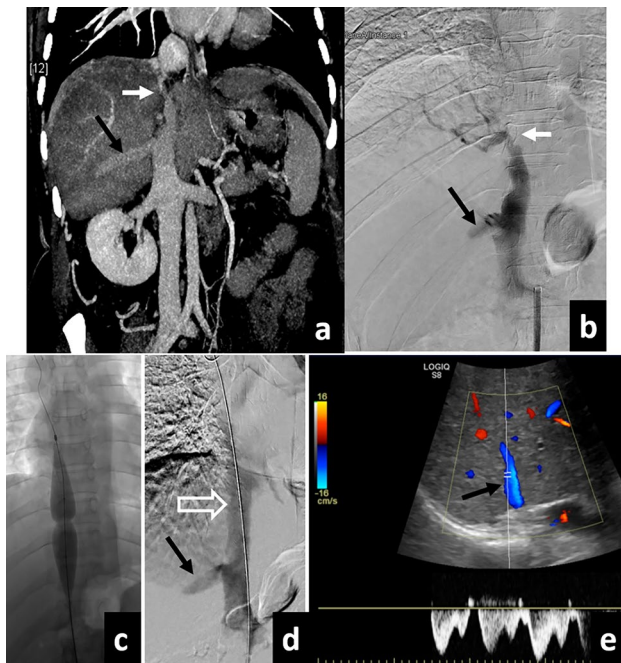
Segmental IVC recanalization through transfemoral route in a patient with abdominal pain and lower limb swelling. a Coronal CECT showing short-segment intrahepatic IVC obstruction due to IVC web and associated chronic eccentric thrombus (white arrow a). The liver was draining mainly through right AHV (black arrow). b IVC venogram confirmed the CT findings (white arrow b). c Stricture was crossed and balloon angioplasty was done using a 20 mm balloon. d Immediate post-angioplasty venogram showing recanalized IVC (open white arrow d) with the normal drainage of AHV (black arrow). e 3-month follow-up USG showing the normal phasic flow in AHV (black arrow), suggesting patent intra and suprahepatic IVC. Symptoms gradually improved over a period of 1 to 2 months. *AHV* Accessory hepatic vein, *IVC* Inferior vena cava
